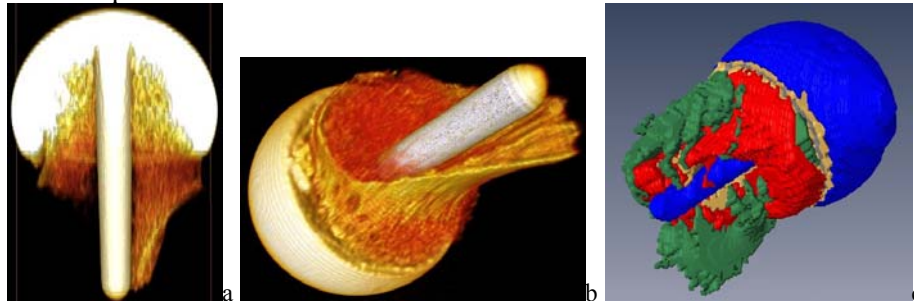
Tomography pictures of the femoral head with resurfacing arthroplasty (a, b) and material modulus differentiation based on CT scan grayscale value (c)
